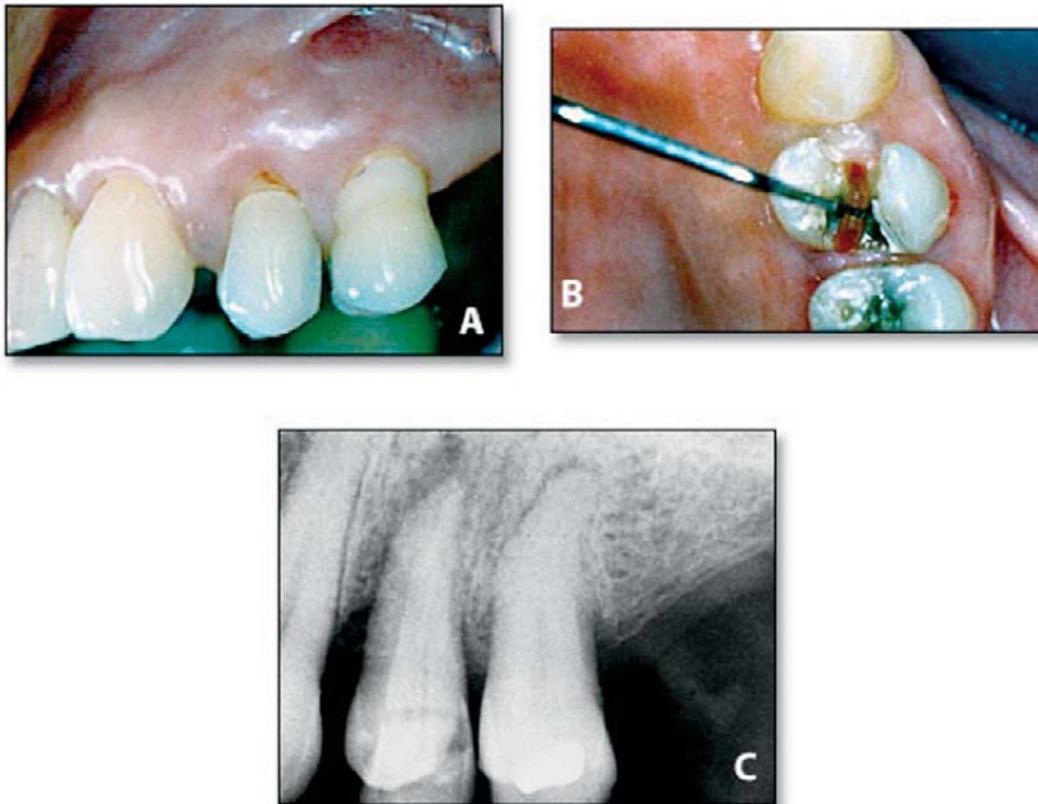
Abscess due to a root fracture. (A) Buccal and (B) Occlusal view; (C) Radiographic characteristics.
